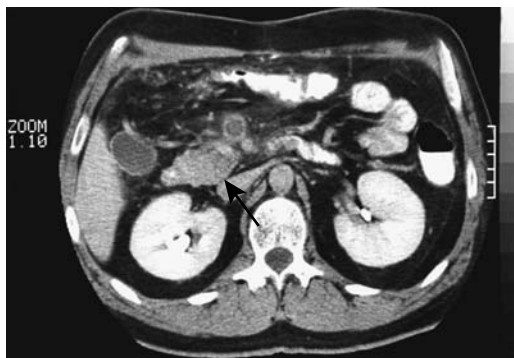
Superior mesenteric vein thrombosis after appendectomy. Contrast-enhanced CT reveals an enlarged vein, an intraluminal clot and an enhancing vein wall (arrow). (Source: Schmutz GR, Benko A, Billiard JS, Fournier L, Péron JM, Fisch-Ponsot C. Computed tomography of superior mesenteric vein thrombosis following appendectomy. *Abdom Imaging* 1998;23: 563–567, with permission from Springer-Verlag.)
